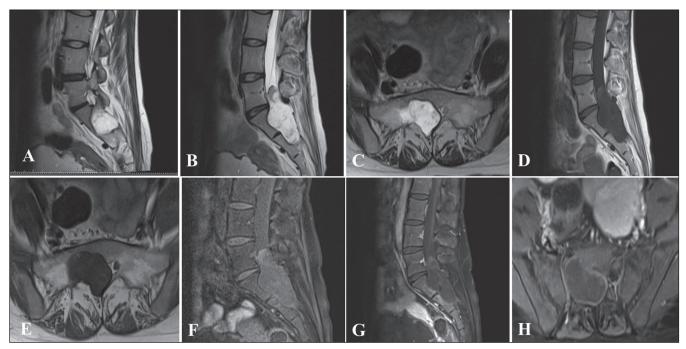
T2-weighted sagittal (A and B) and axial (C) MR images showing a predominantly hyperintense tumor extending from L5 to S2 levels. Scalloping of the S1 and S2 vertebrae is noted. T1 weighted sagittal (D) and axial (E) images showing a hypointense tumor. Postcontrast fat suppression images (G and H) showing mild peripheral enhancement (F)
